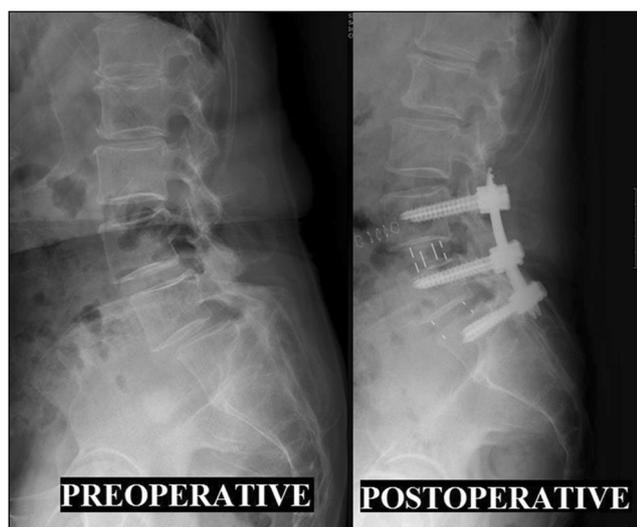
Preoperative and postoperative X-rays showing excellent reduction of listhesis and restoration of disc height. This patient had undergone OLIF L4L5 and L5S1
